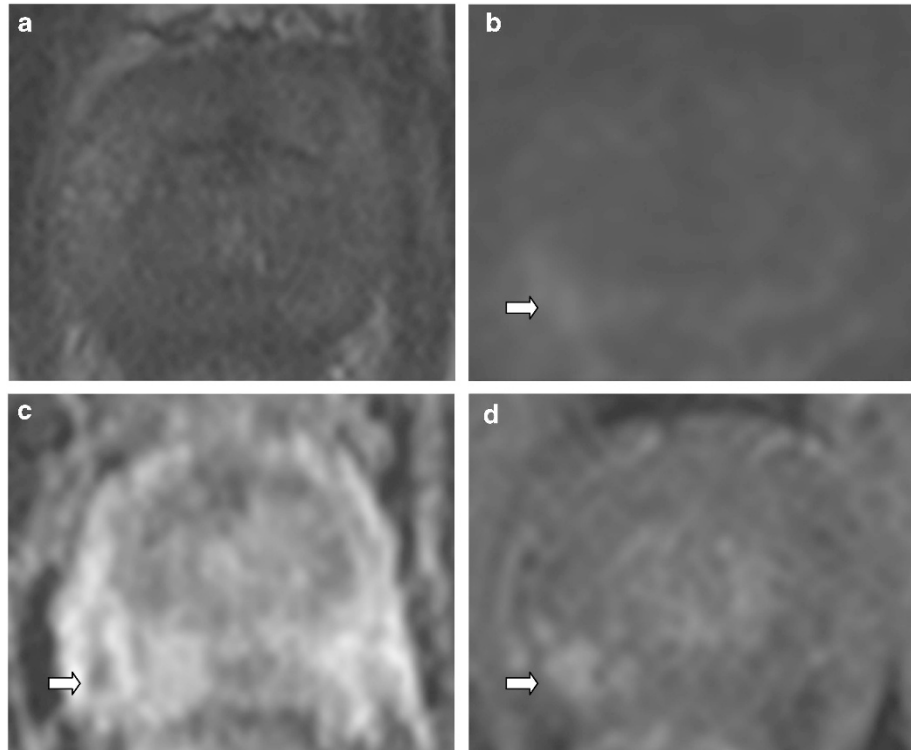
Axial images from a 68-year-old patient with positive MRI (scoring 5/5), nine positive cores with a maximum cancer core length of 6 mm, 50%, Gleason 3+4 were present at template prostate mapping (TPM) biopsy in the right lateral zone. Both the readers scored the right hemigland as: 3/5 on T2 weighted (a); 4/5 on b1400 (b); on apparent diffusion coefficient (ADC) (c); and 5/5 on dynamic contrast-enhanced (DCE) imaging (d). The left hemigland was scored by readers 1 and 2 as: 3/5 and 3/5 on T2 weighted (a); 2/5 and 2/5 on b1400 (b); 2/5 and 2/5 on ADC (c); and 2/5 and 1/5 on DCE (d). No cancer was present in the left hemigland on TPM biopsy.
